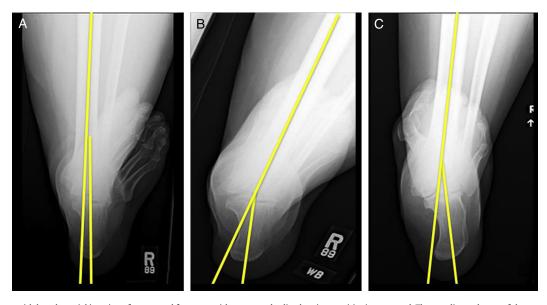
Variable outcomes with long leg axial imaging of a pronated foot type without a standardized patient positioning protocol. These radiographs are of the same patient with posterior tibial tendon dysfunction standing in angle and base of gait. Variations resulted from changing the position of the x-ray tube and cassette in relation to the foot and leg. (A) The natural tendency with pronation deformity is to image the foot externally positioned in relation to the tibia, which inadvertently will not capture heel valgus. Note, the too many toe sign with the rectus heel. (B) The x-ray tube was then rotated to superimpose the tibia through the second metatarsal, properly demonstrating the valgus heel position. However, the tibia was angulated on the screen, which negatively affected visual assessment of the radiograph. (C) Angulation of the tibia was corrected by rotating or moving the patient's entire body to position the second metatarsal (or lateral edge of the imaged foot) with the edge of the cassette. This final image accomplished the desired goals of the tibia imaged through the second metatarsal, the tibia vertical on the screen, and the patient positioned in angle and base of gait with both heels in the resting calcaneal stance position.
